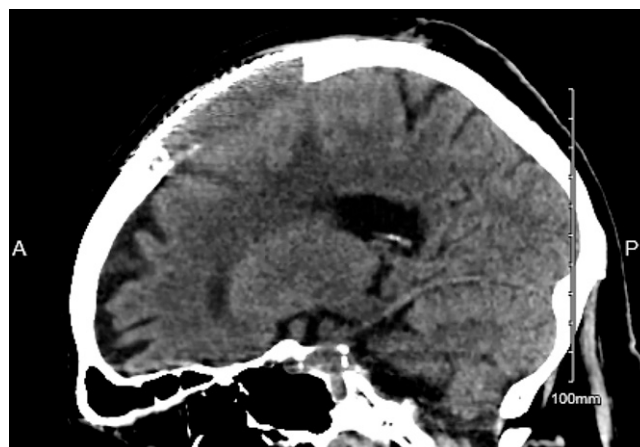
Postoperative CT of the head after release of dura and reconstruction.
